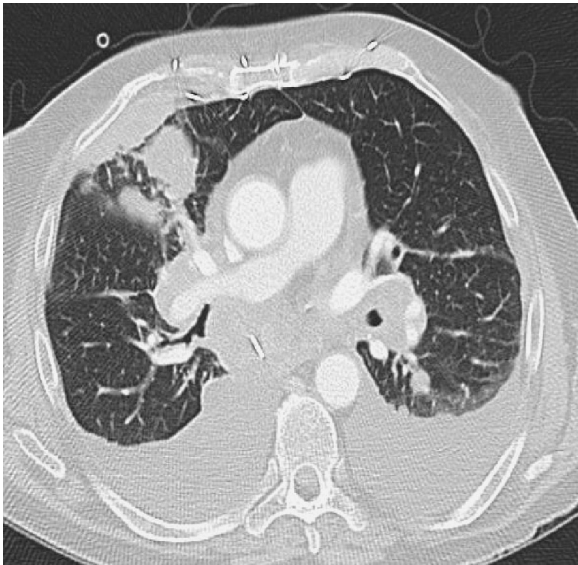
Chest CT showing right middle lobe mass.
